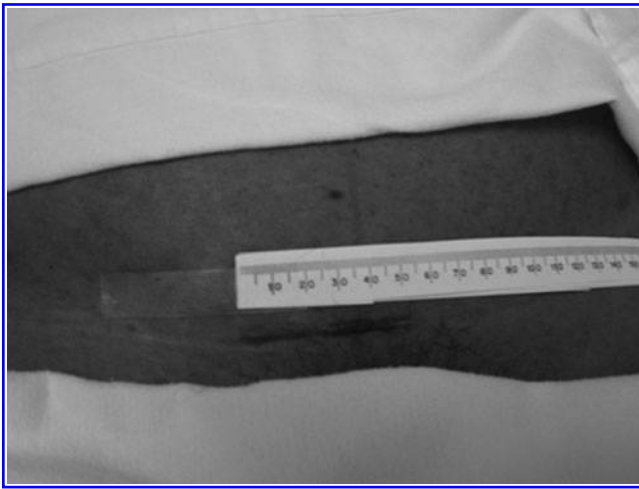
A postoperative picture showing a 5-cm transverse suprapubic scar from the minilaparotomy. Taken from ISBN: HB 9781107029743. Edited by Botros R.M.B. Rizk and Elizabeth Puscheck. *Ultrasonography in Gynecology*. Figure 18 in the book chapter "Transvaginal ultrasound scan findings of uterine fibroid effect on treatment plan." By Dr. Mostafa Abuzeid and Salem Joseph. Copyright © 2012 Cambridge University Press. Reprinted with the permission of Cambridge University Press.
